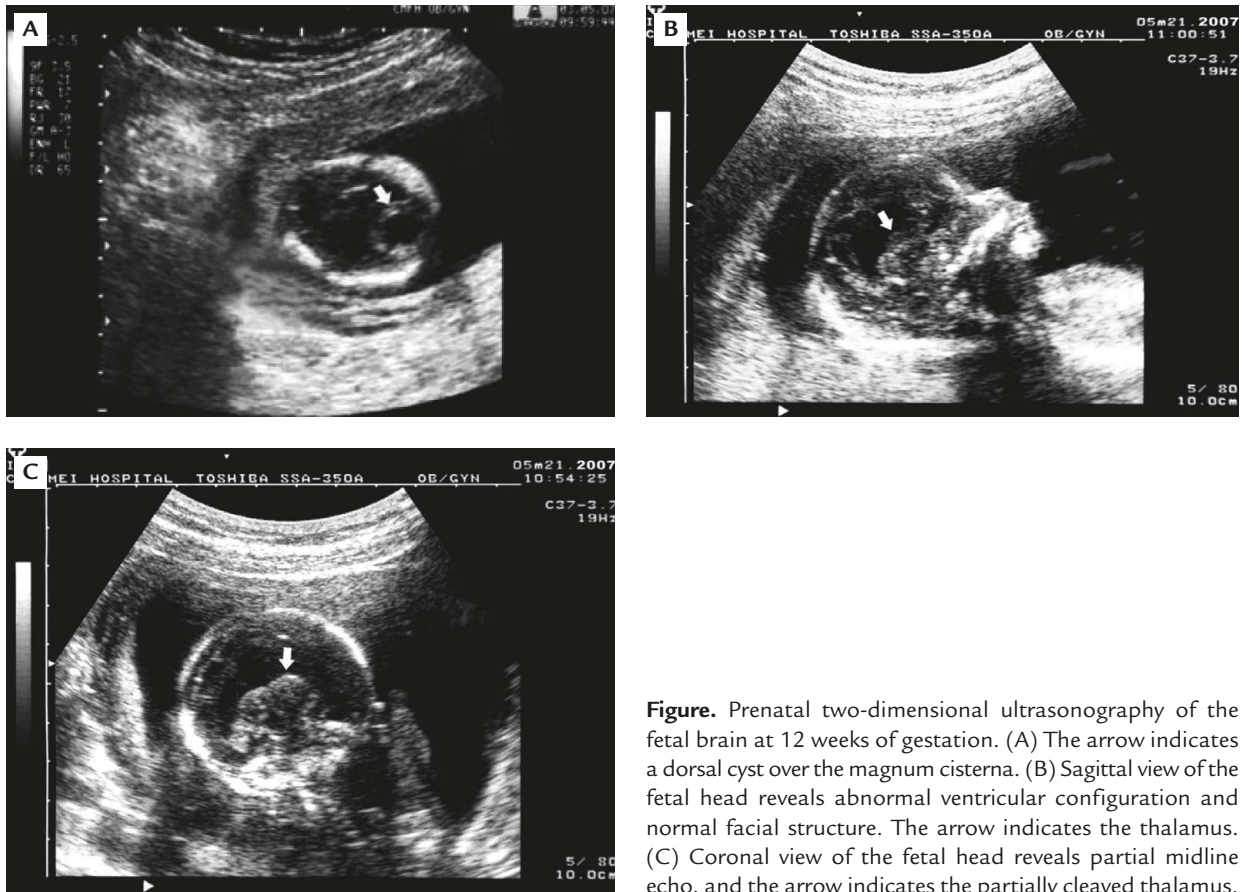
Prenatal two-dimensional ultrasonography of the fetal brain at 12 weeks of gestation. (A) The arrow indicates a dorsal cyst over the magnum cisterna. (B) Sagittal view of the fetal head reveals abnormal ventricular configuration and normal facial structure. The arrow indicates the thalamus. (C) Coronal view of the fetal head reveals partial midline echo, and the arrow indicates the partially cleaved thalamus.
